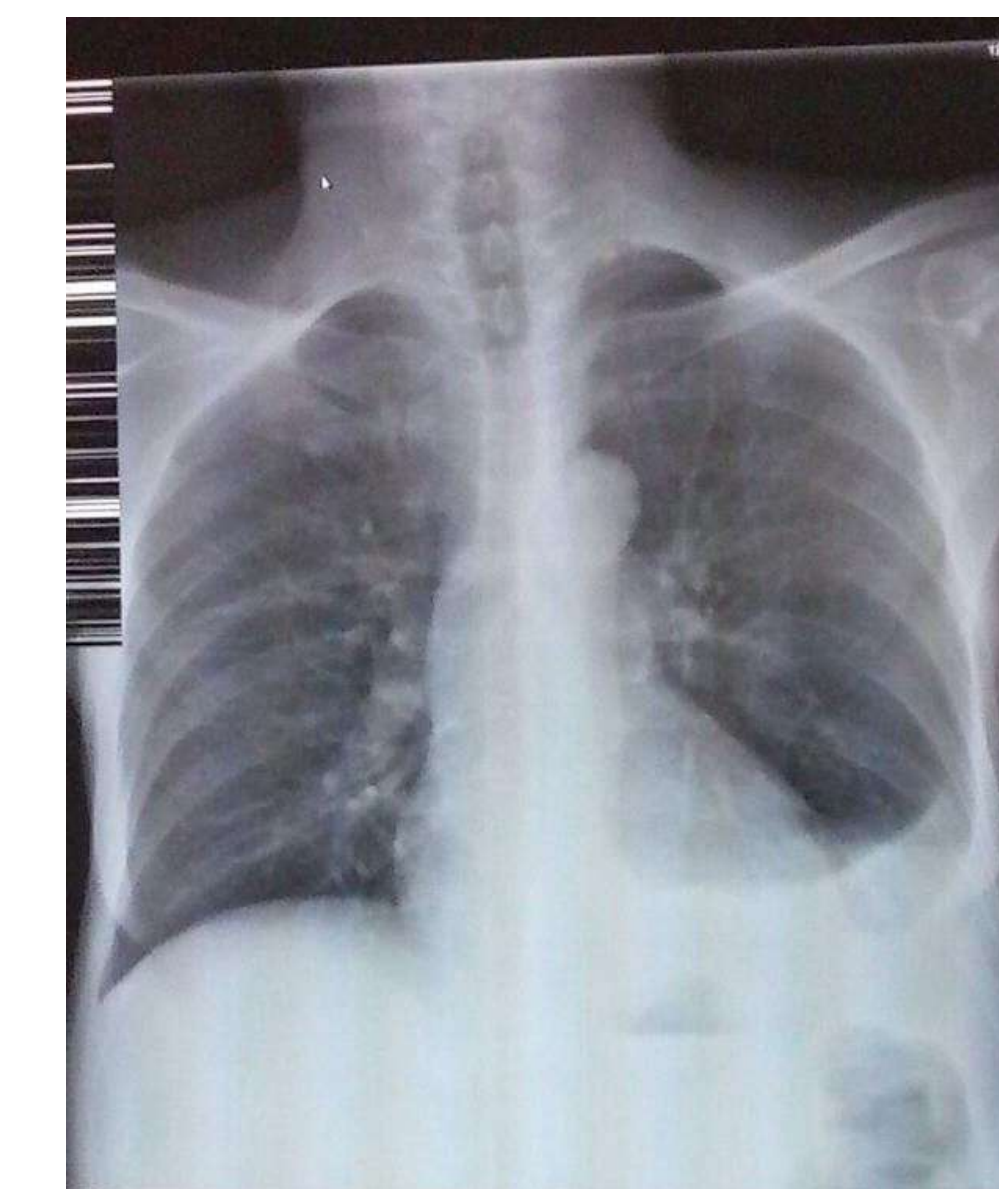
Lung CT evaluation after LT, pleural fluid resorbed
